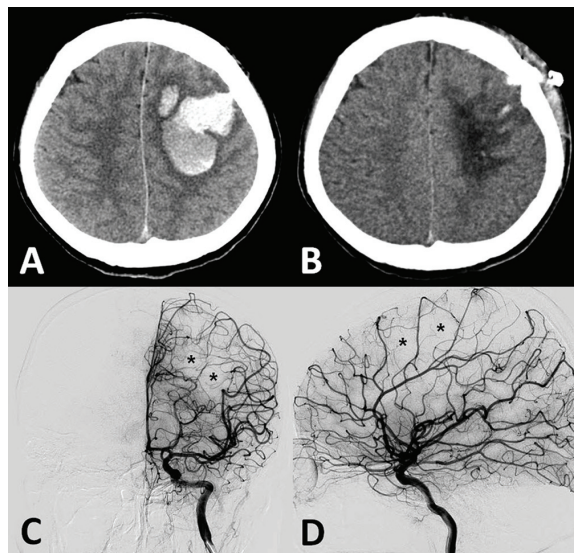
Axial non-contrast enhanced cranial CT showing: (A) the left frontal lobe hematoma with minimal midline shift; and (B) disappearance of the hematoma following a surgical removal through the left frontal craniotomy. DSA of the left internal carotid artery in anteroposterior (C) and lateral (D) views before the surgical evacuation showing the avascular area (asterisk) occupied by the retained hematoma without identifiable vascular lesion
